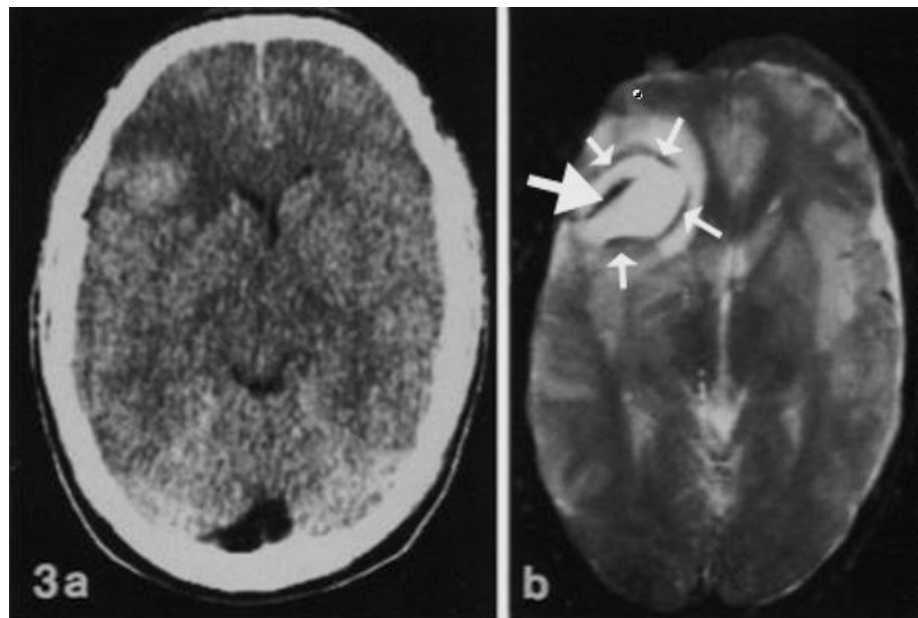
Upper: CT scan (left) and long TE gradient echo (right) images of a subacute haematoma. The lesion is better seen with the T_2^* weighted gradient echo image and has a central low signal (dark) region (large arrow) as well as a peripheral dark rim (small arrows).
